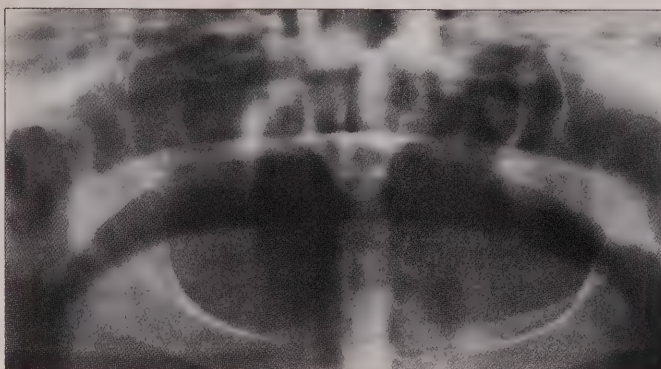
Panoramic radiograph of a 10-year dislocated right condyle (Case 1).
